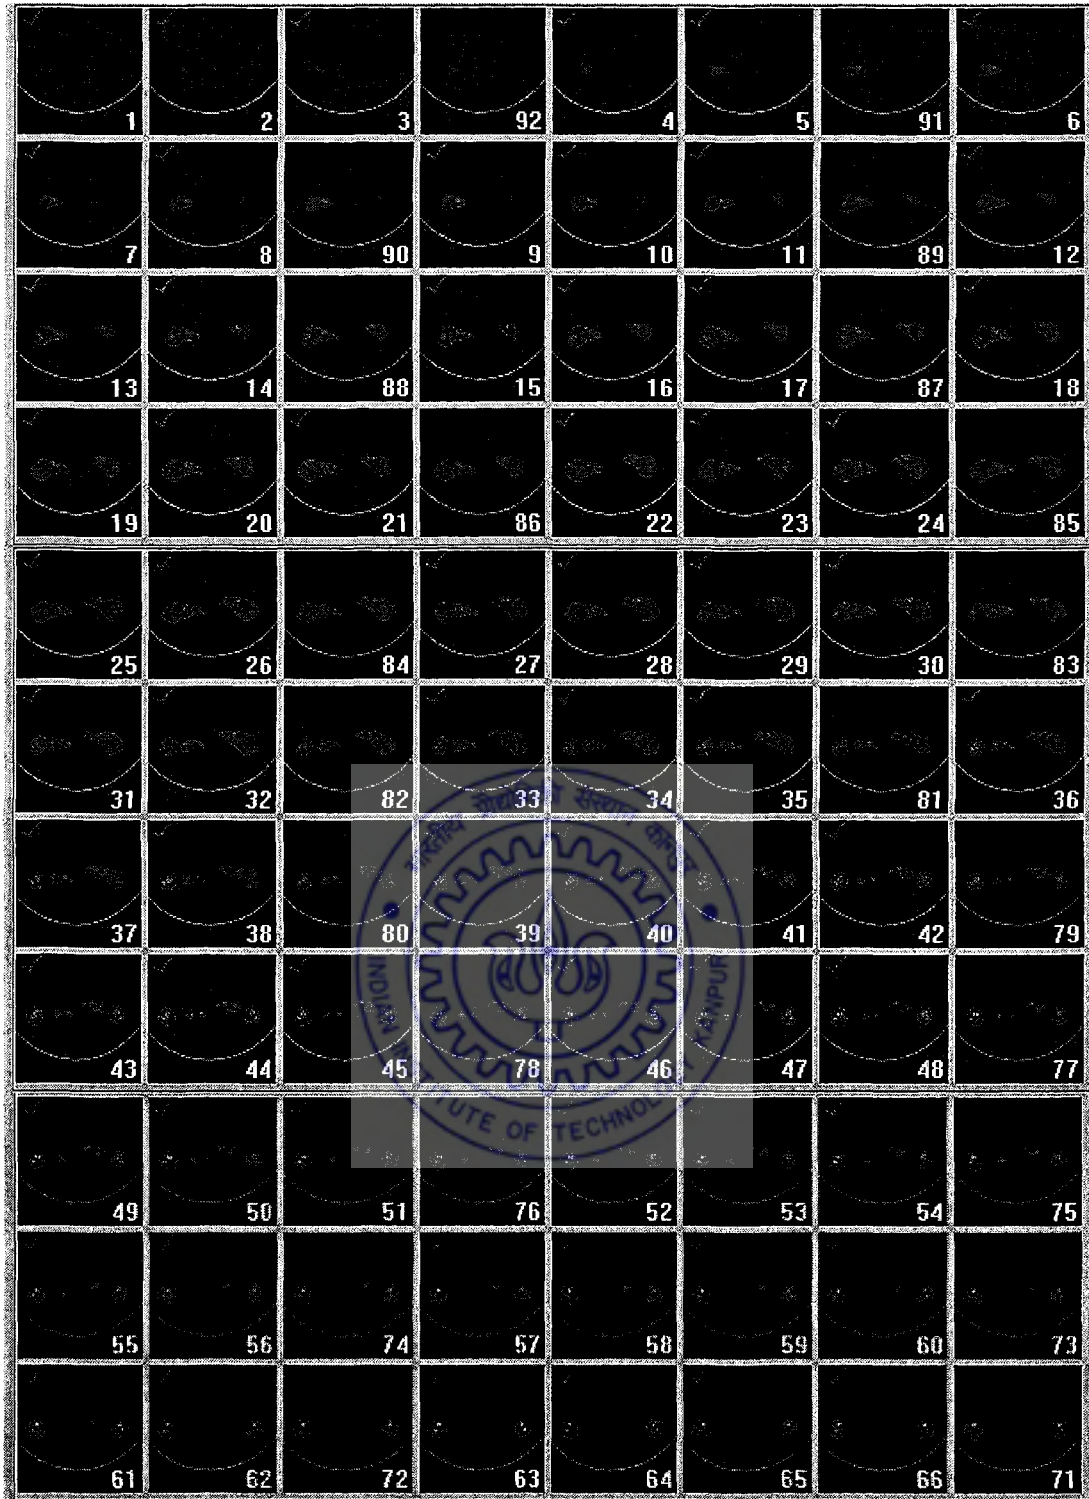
MRI scan data of clubfoot of Patient I
